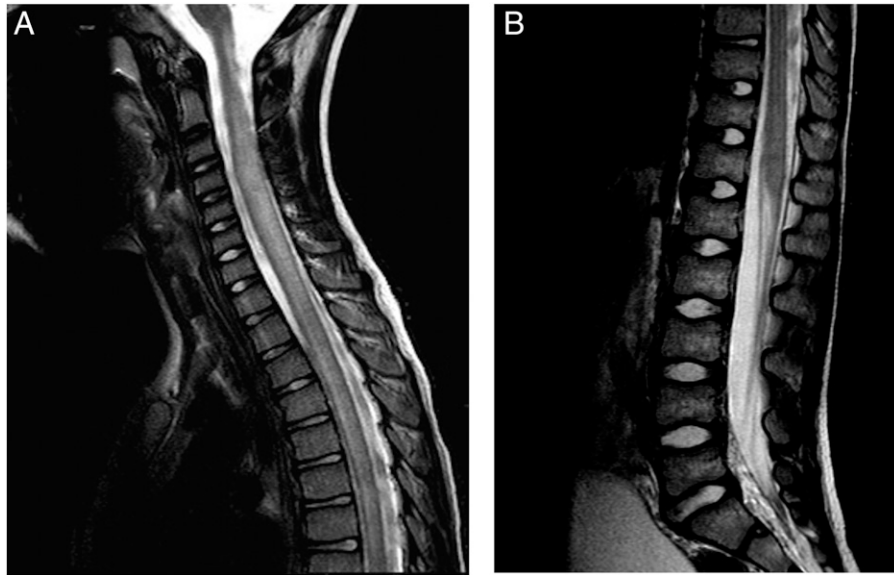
Magnetic resonance images of the spine show a hyperintense T2-weighted signal in the spinal cord from the cervicomedullary junction to the conus medullaris (20 vertebral segments). The signal abnormality involves gray and white matter of the central and posterior portions of the cord. A. Cervicomedullary junction to the eighth thoracic vertebra. B. Ninth thoracic vertebra to the conus medullaris, which ends at the first lumbar vertebra.
